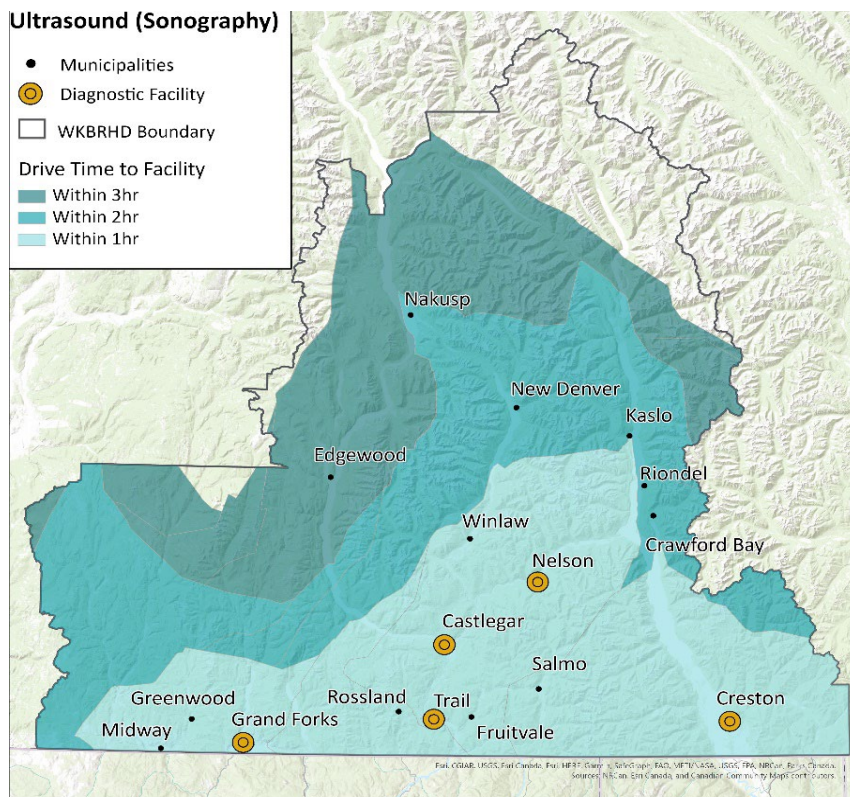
Service area distances to ultrasound (sonography) diagnostic facilities within the WKBHRD
